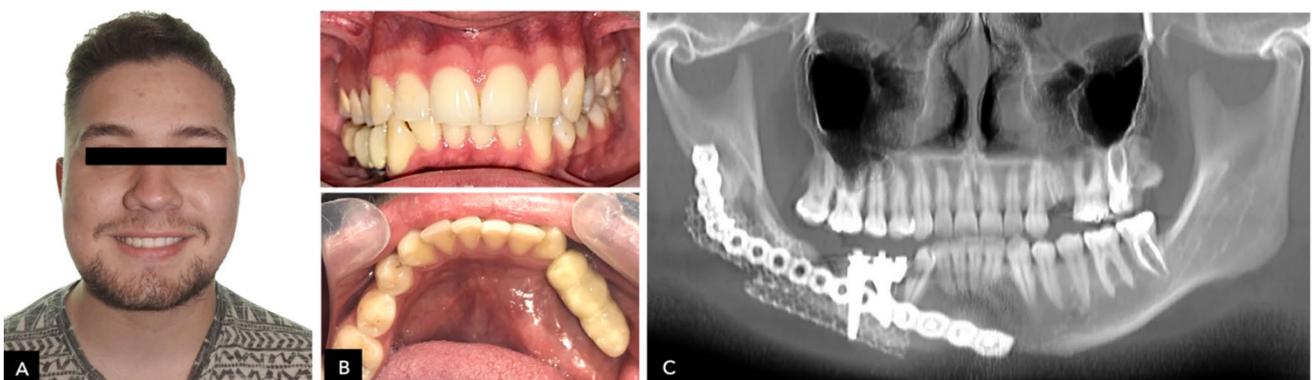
Five-year postoperative follow-up of the patient. a Facial view, b intraoral images, with proper occlusion, c 5-year post-surgery follow-up cone beam CT with dental implants in bone regenerated with TE. No further complications
